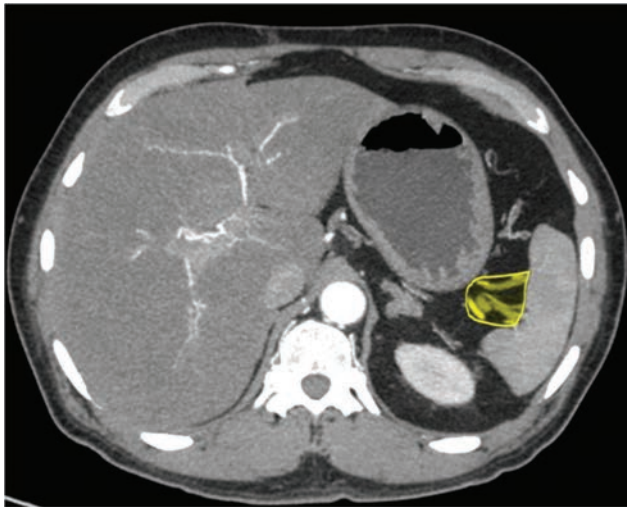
Station 10. Axial computed tomography in arterial phase depicts the station 10 location at splenic hilum (yellow area). When involved, it may require splenectomy.
